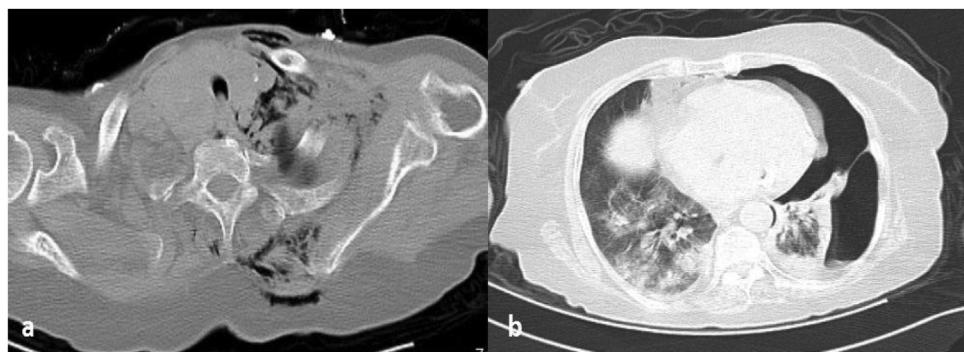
Axial CT scan of the level of superior thoracic aperture in mediastinal window: (a) subcutaneous emphysema between the deep structures of neck and posterior thoracic wall. Axial CT scan of the thorax in lung window; (b) massive left-sided pneumothorax. Bilateral ground glass patchy opacities are also seen representing COVID-19 lung involvement.
